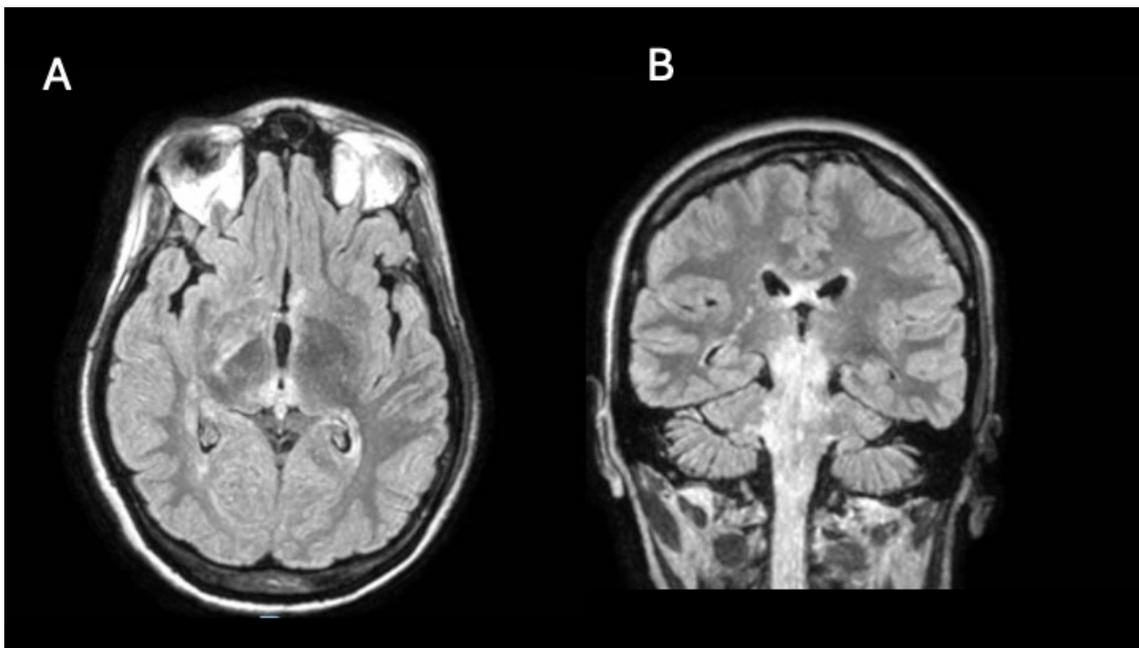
Imagem de RM de encéfalo em sequência FLAIR com A- corte axial; B- corte coronal: demonstrando alteração de sinal em região em diencéfalo, região Peri-terceiro ventrículo e tronco encefálico e medula cervical. Paciente 35 anos DENMO Anti-AQP4+.
